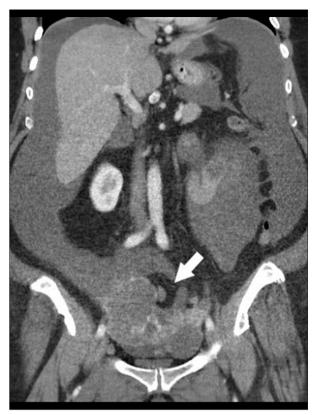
Coronal contrast-enhanced CT shows large ascites throughout the abdomen, displacing the organs centrally as well as the large cystic/solid ovarian mass (white arrow) in the pelvis. CT – computed tomography.
